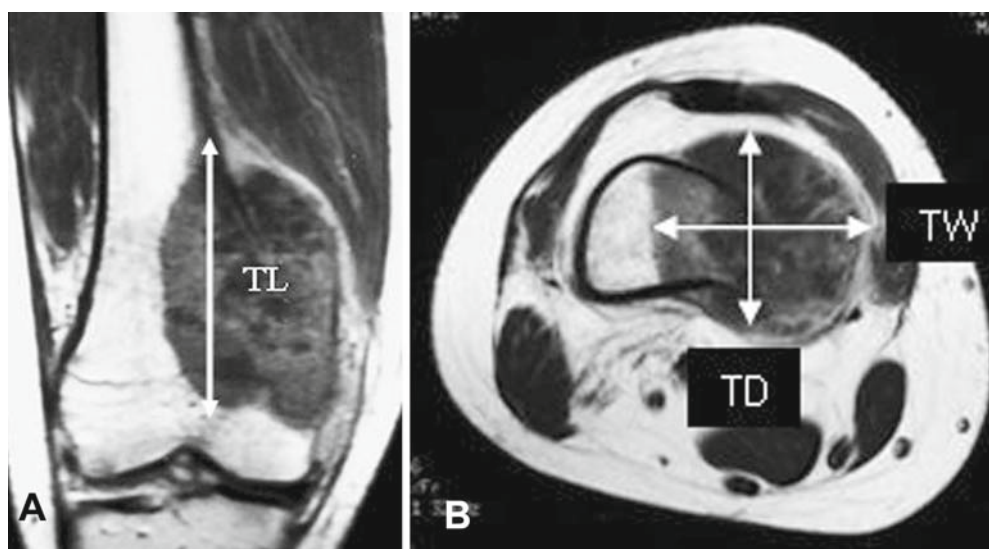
A Tumor length (*TL*) was measured in coronal sections of unenhanced T1-weighted sequences. B Tumor width (*TW*) and depth (*TD*) were measured in axial sections of enhanced T2-weighted sequence without fat suppression. Tumor volume was calculated by an ellipsoidal formula: Tumor volume = $\pi \times TL \times TW \times TD/6$
